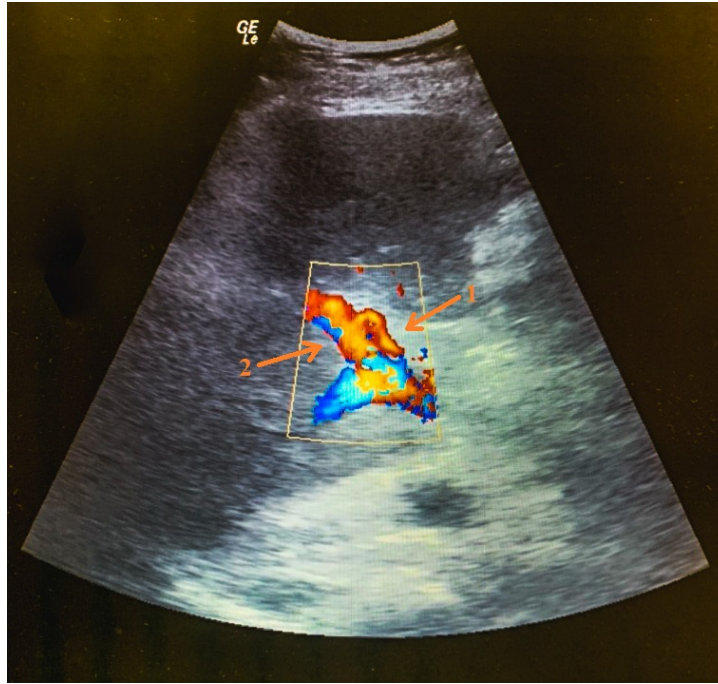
Ultrasound imaging of the hepatobiliary system vessels of the on day 5 after OLT
